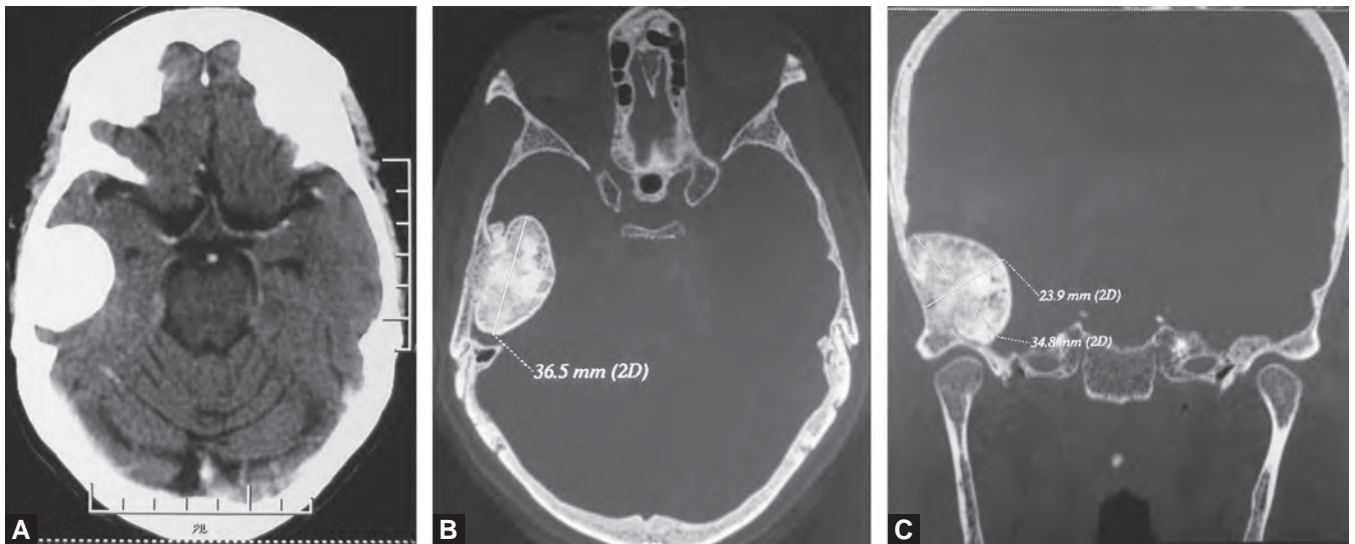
CT bone cuts and reconstruction showing osteoma of the right occipital region
